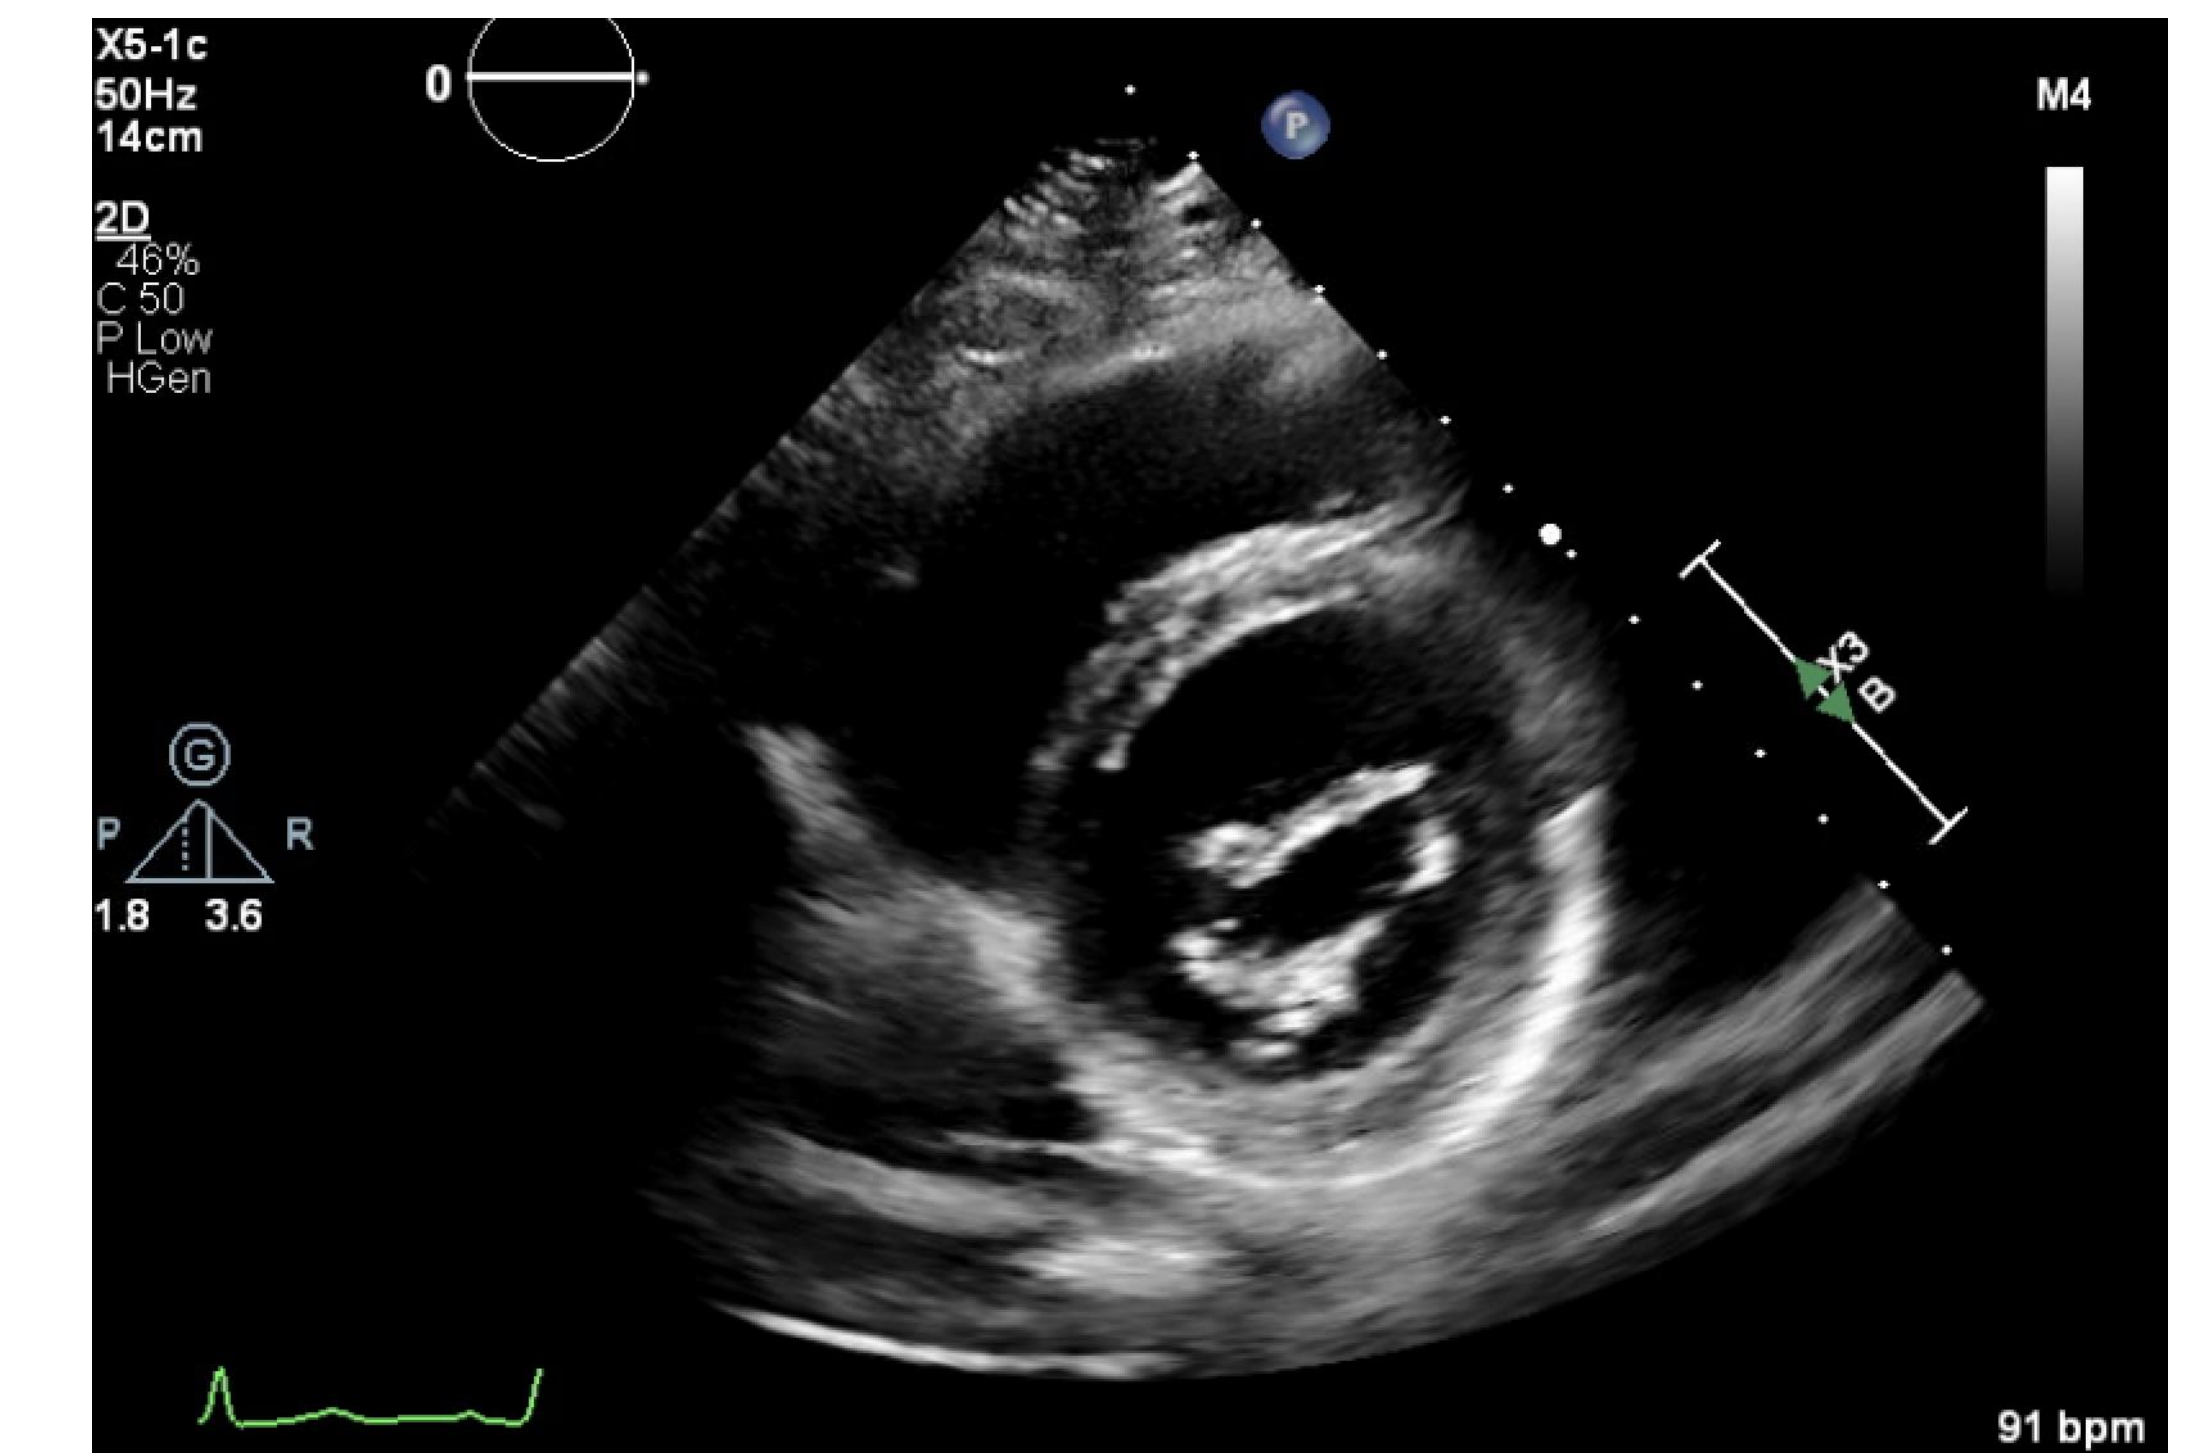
Parasternal short axis view of mitral valve
